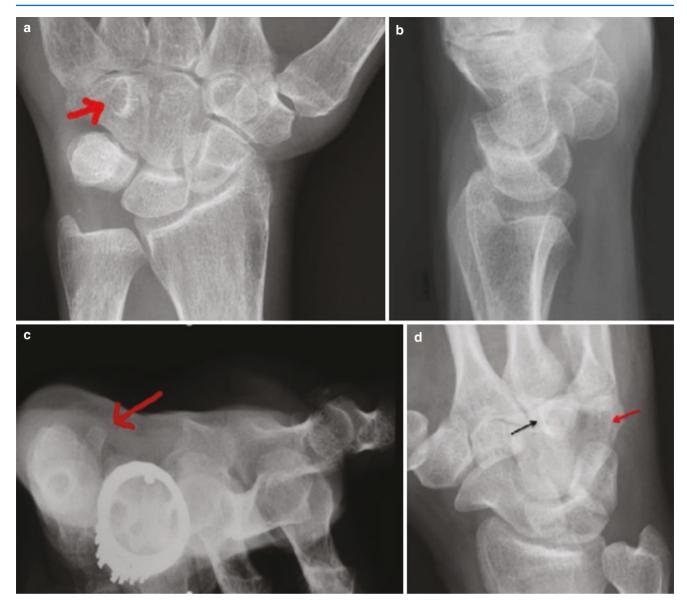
(a) Shows posteroanterior (PA) view and (b) shows lateral wrist and carpal tunnel radiographs of a subtle hook of hamate fracture. The red arrow on the PA view demonstrates a "ring sign" or discontinuity of the cortical ring of the hook of hamate. The hook of hamate is difficult to visualize on the lateral radiograph. Although the hamate
